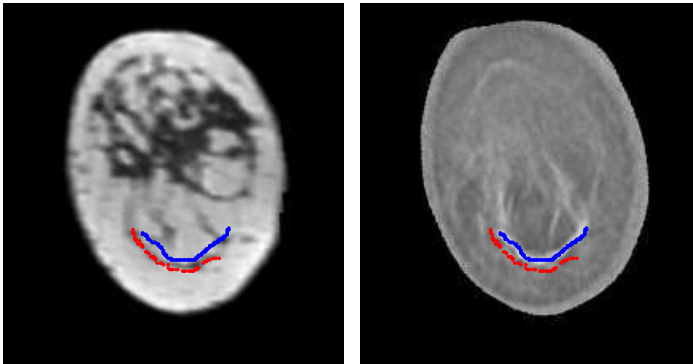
Result of the registration with strategy A. MRI (left) and USCT (right), each with markings of a connective tissue structure, which served as a basis for evaluation of the TRE. Blue denotes the surface points of the marking in USCT, red denotes the surface points of the marking in MRI. Note that both images show the same coronal slice from the 3D volumes.
